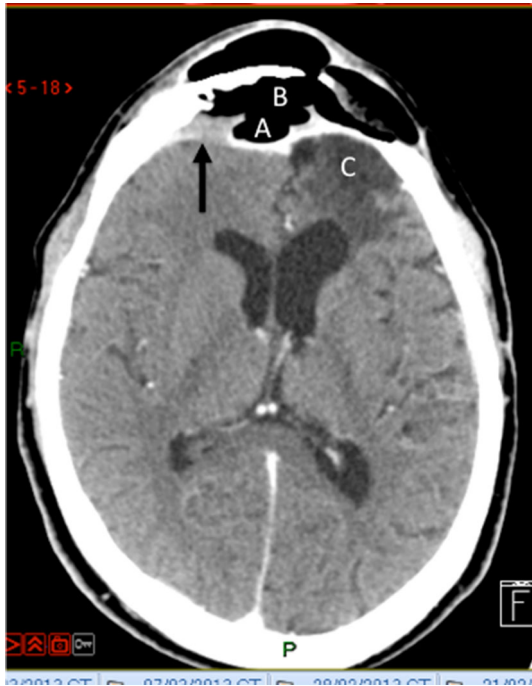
Brain computed tomography scan showing the frontal sinus (A), the epidural pneumocephalus (B), and the abscess (C). The arrow indicates the dural border
